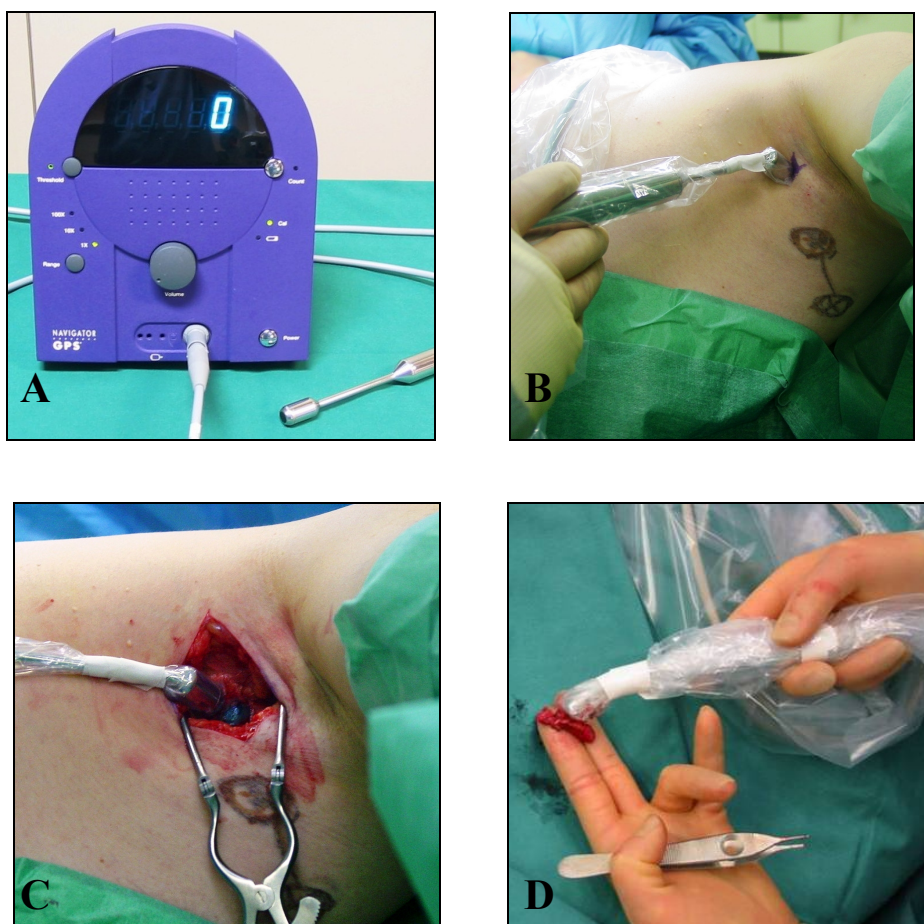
Sentinel lymph node biopsy: A. Gamma detecting probe. B. Radioactive focus in the right axilla, dorsally to the lymphoscintigraphy skin markings. C. Blue and hot node is found. D. Ex vivo radioactivity counted from the hot node.
